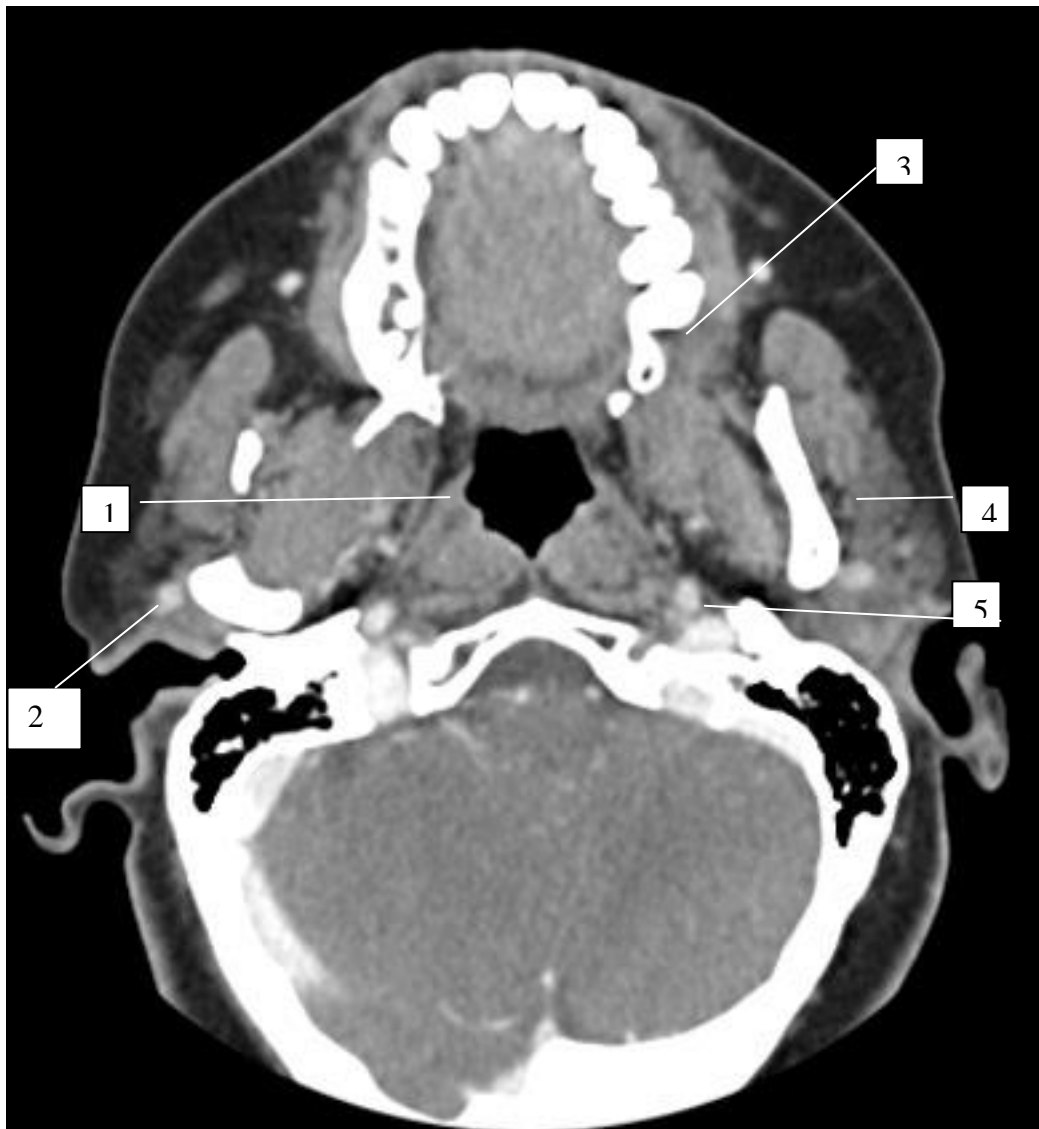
depict the cross-sectional CT anatomy in evaluation of head and neck<sup>11</sup>.
